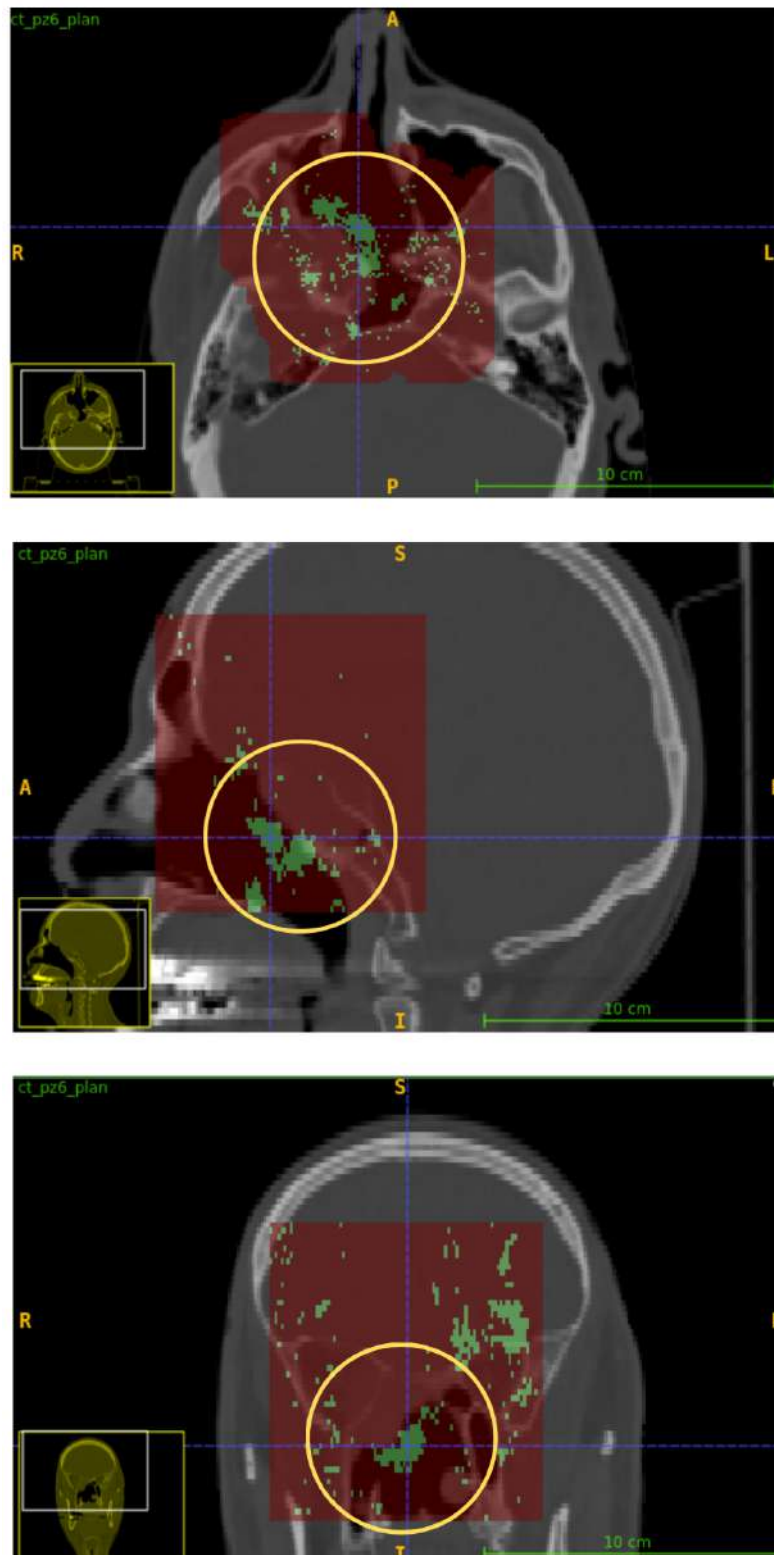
Pass rate map for  $DD = 0.25\%$ ,  $DTA = 20$  mm,  $DTH = 0\%$ , showing the deep and large morphological variation (yellow circle) in axial, sagittal and coronal views (from top to bottom), overlaid on the planning CT.
